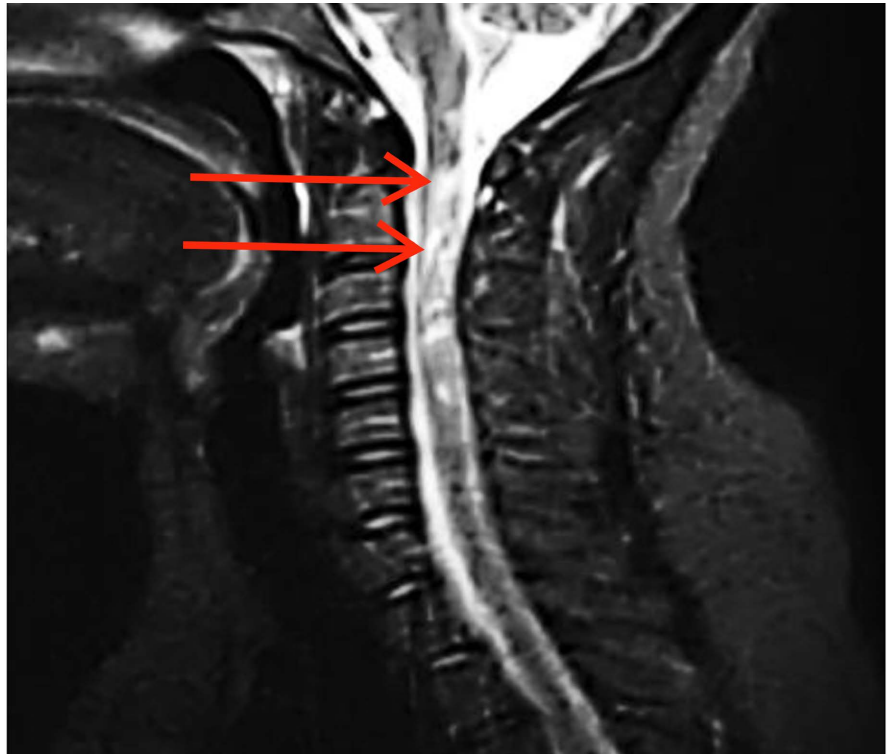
Spinal cord MRI of Case 2 showing extensive T2 hyper signal over more than 3 vertebrae (red arrows).
